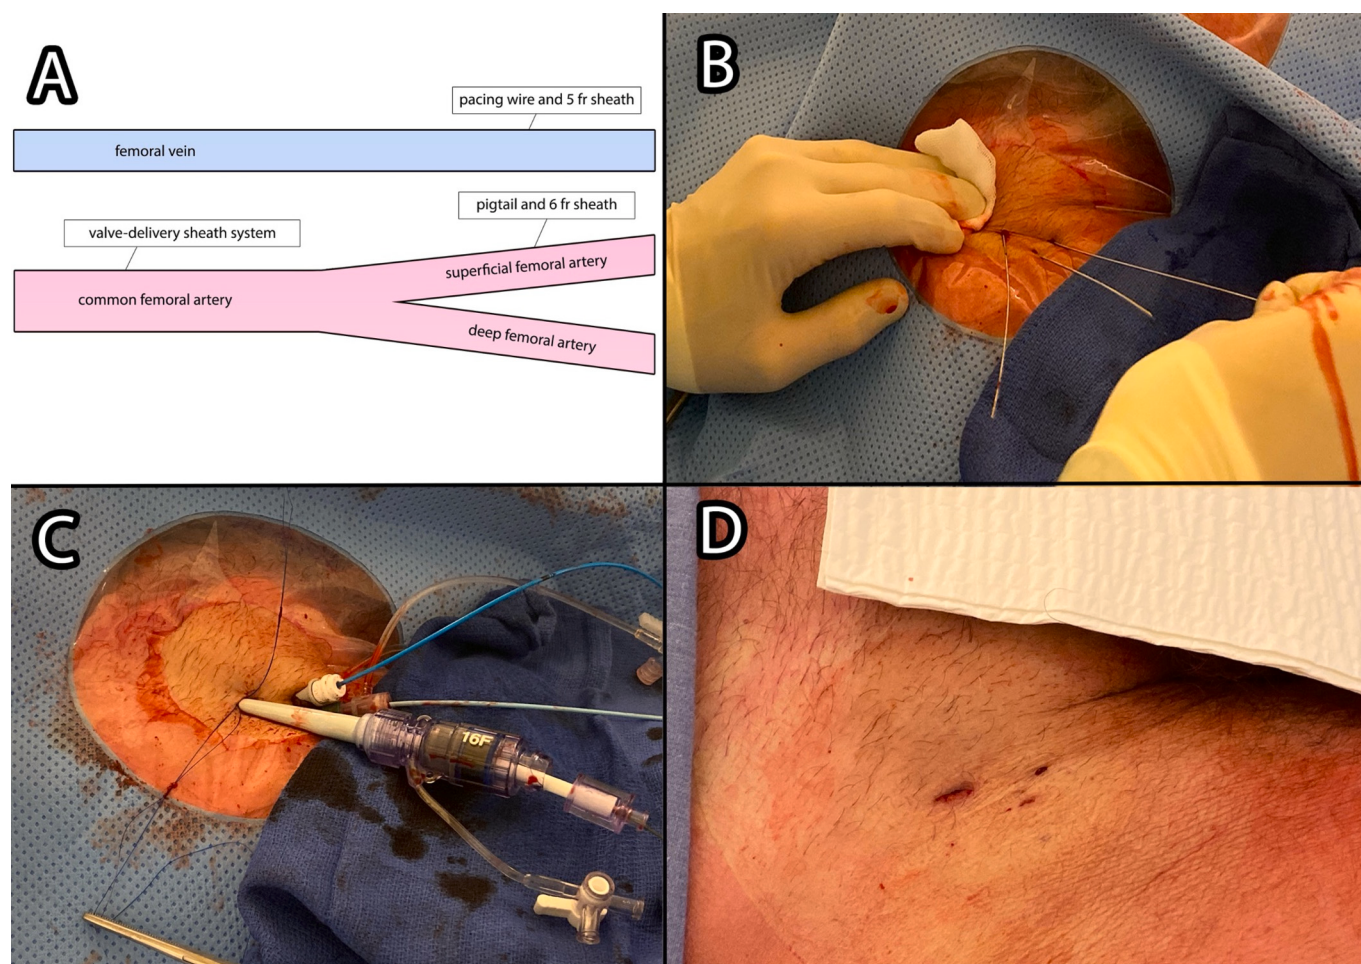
Unilateral-access transfemoral technique. A) In unilateral-access group, main femoral arterial access is obtained in the common femoral artery (CFA); secondary arterial access is placed at the ipsilateral superficial femoral artery (SFA) and venous access for transvenous temporary pacemaker is placed at the ipsilateral femoral vein (except when pacing is performed with the delivery wire). B) Guidewires in place after ultrasound-guided femoral punctures; C) 16Fr valve delivery system is placed at the main femoral arterial access (CFA), 6Fr sheath and pigtail catheter for aortic root angiography are placed at the secondary arterial access (SFA); optional: 5Fr sheath and transvenous temporary pacemaker are placed at the ipsilateral femoral vein. Note that two preclosing suture-based devices are being used at the delivery system site. D) Final result after arterial and venous sheaths removal and hemostasis. CFA – common femoral artery; Fr – French; SFA – superficial femoral artery.
